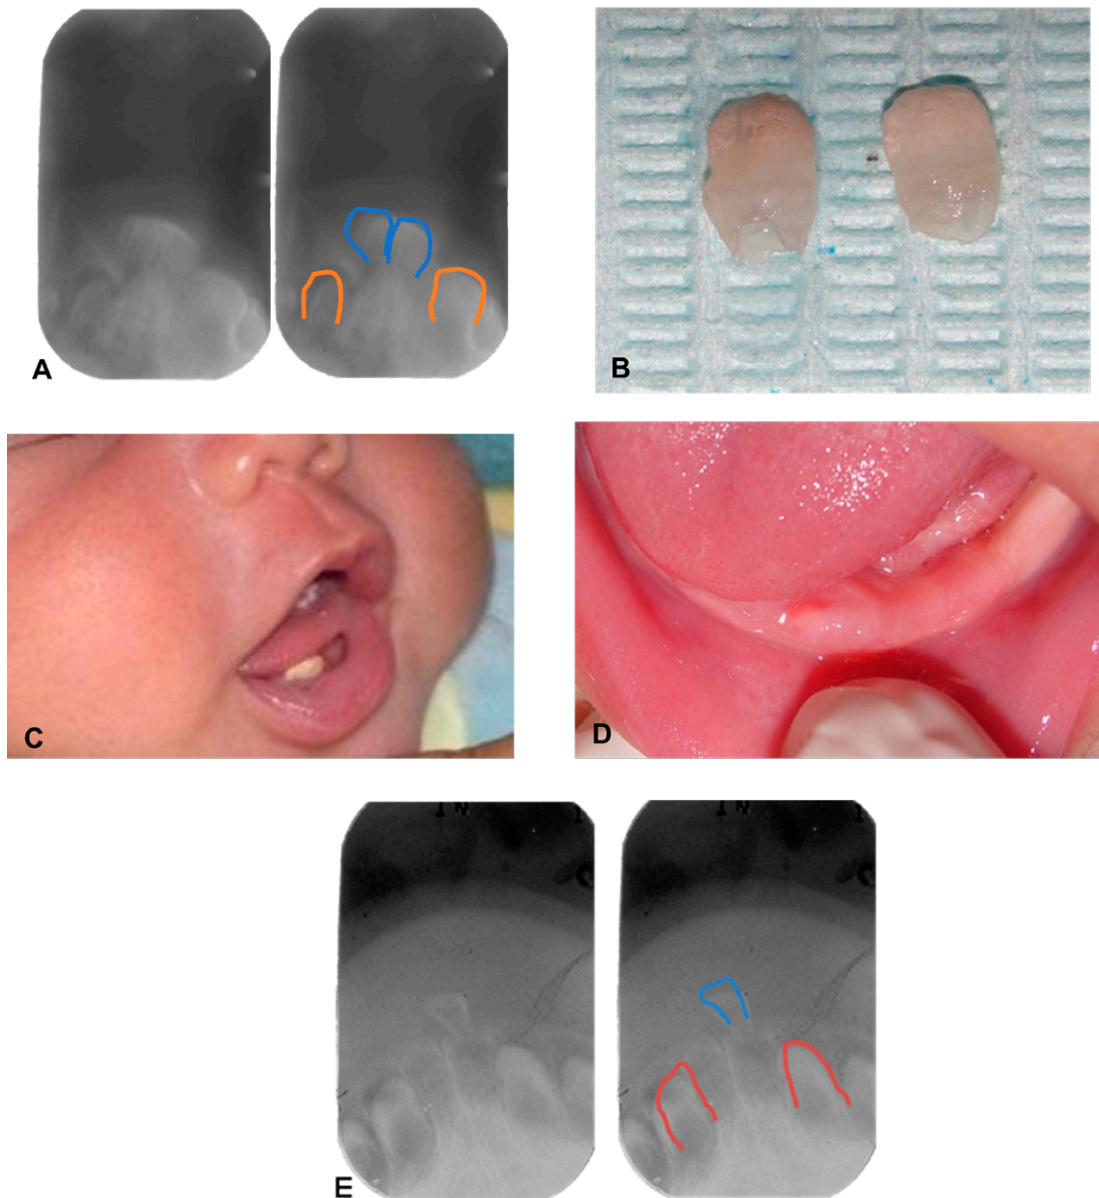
Clinical procedure. A. Dentoalveolar radiography, showing the natal teeth, right image 71 and 81 (blue), 72 and 82 (red). B. Teeth 71 and 81 without root presence, after extraction. C. Evolution after the surgical procedure, with the presence of milk residue. D. Increased volume in the lower alveolar ridge. E. Dentoalveolar radiograph, showing an RNT, right image 71 (blue), 72 and 82 (red).
